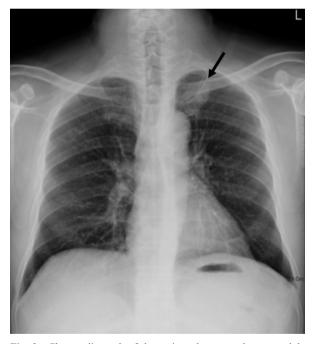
Chest radiograph of the patient shows an obscure nodule (arrow) in the left upper lobe of the lung.
